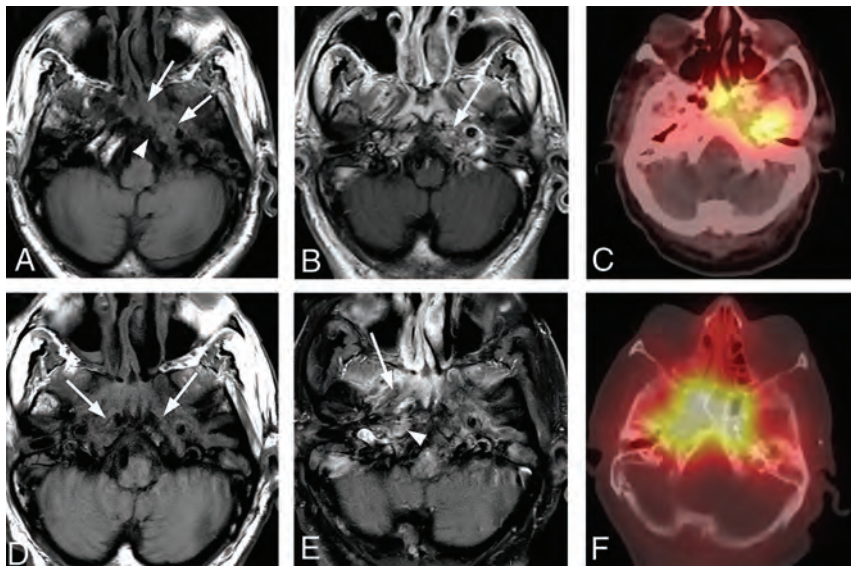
Progressive left-sided skull base osteomyelitis. A 65-year-old man with multiple comorbidities, including poorly controlled diabetes, presented with a relatively long-standing history of chronic sinusitis and bilateral otitis media. He was recently treated for otitis media of the left ear and presented with new headache and left-sided hearing loss. Culture from the left EAC was negative for a causative organism, and cultures from the sphenoid sinus demonstrated methicillin-resistant *S aureus*. The patient was treated with 4 weeks of IV vancomycin and piperacillin/tazobactam. The patient improved, and a gallium scan performed during follow-up showed significant improvement and only mild residual uptake in the skull base. Antibiotics were discontinued. The patient returned 4 weeks later with sepsis, and blood cultures were positive for *Klebsiella* species. In the next 3 months, the patient had a return of headaches and new right-sided symptoms. Imaging evaluation demonstrated progressive infection of the right skull base. Re-institution of IV antibiotics led to gradual resolution of clinical and imaging findings. A, Axial T1-weighted MRI through the skull base shows an infiltrative soft-tissue abnormality (arrows) involving the central skull base with abnormal marrow signal on the left side of the occipital bone (arrowhead). B, Axial enhanced T1-weighted MR image shows heterogeneous enhancement in the corresponding areas of the left petro-occipital fissure (arrow). C, Axial bone scan fused with CT shows radiotracer accumulation in the left central skull base, including the sphenoid bone and left petrous apex. D, Following initiation of empiric IV antibiotic treatment, the patient had improvement of symptoms on the left, but 4 months later, he developed severe headache, fever, and right-sided facial pain. Axial T1-weighted image shows an infiltrative process (arrows) of the central skull base that now extends to the right. E, Axial enhanced fat-saturated T1-weighted image demonstrates improved enhancement of the left central skull base and the adjacent soft tissues but interval worsening of enhancement of the right skull base (arrowhead) and soft tissues of the nasopharynx (arrow). F, Follow-up axial fused bone scan SPECT image demonstrates radiologic worsening with marked radiotracer uptake in the central skull base in the right petro-occipital region.
